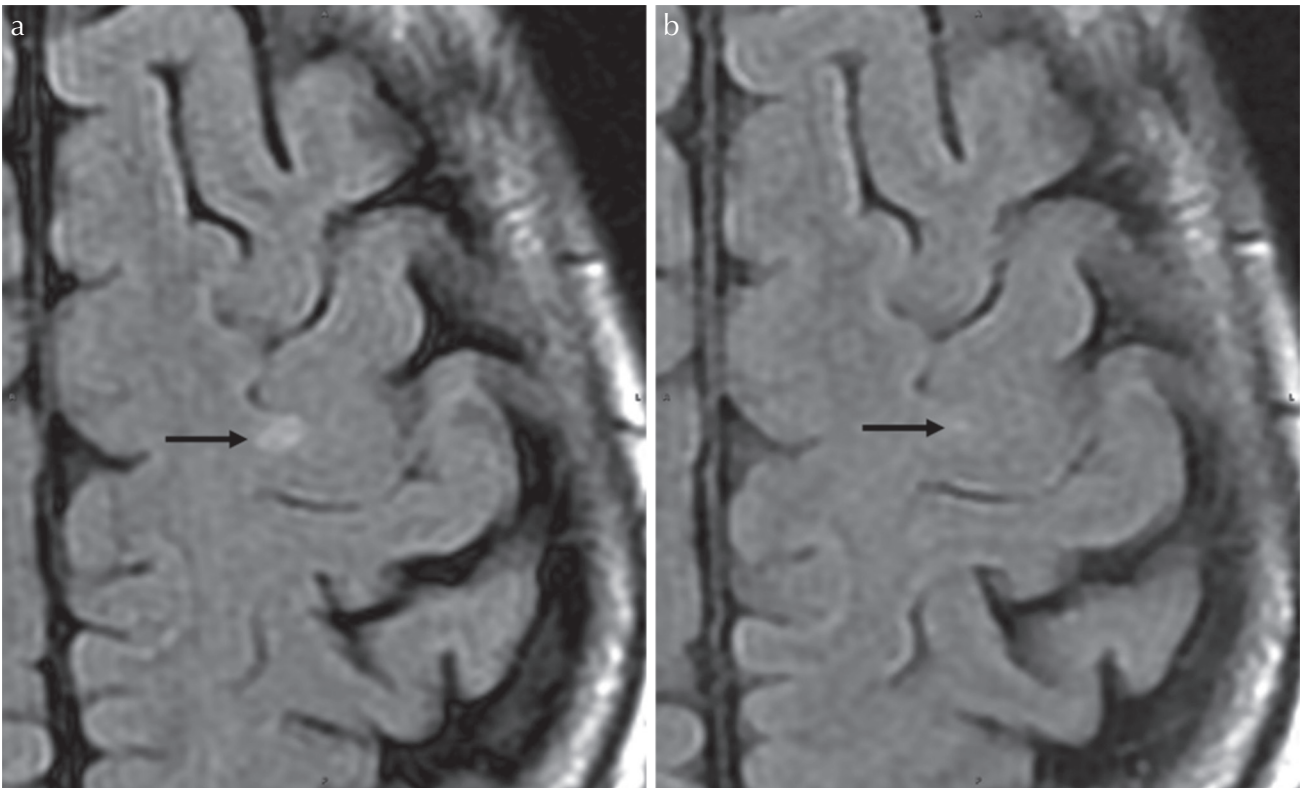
(a) An axial FLAIR image of the first MRI examination obtained from a 68-year-old woman with hypertension, diabetes, liver dysfunction, hyperlipidemia and insomnia, (b) an axial FLAIR image performed 5.42 years after the first MRI examination. A patchy hyperintensity (arrow) in the left frontal lobe in (a) is remarkably decreased in (b) (arrow).
